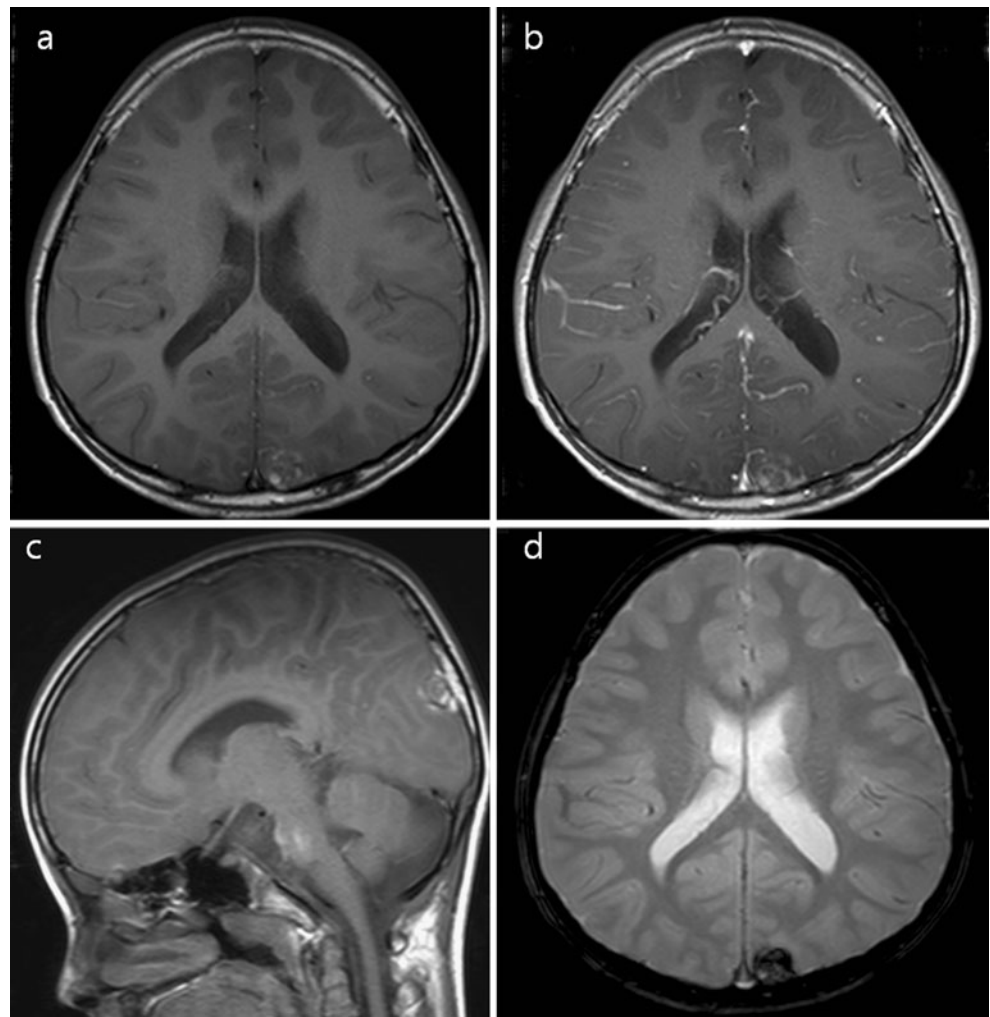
Preoperative magnetic resonance images demonstrating an occipital mass lesion. (a) T1-weighted axial image showing a mass lesion with heterogeneous signal intensity. (b) T1-weighted axial image with contrast enhancement. (c) T1-weighted sagittal image indicating a hypo-intense rim surrounding the mass lesion. (d) Dark signal in gradient-echo protocol suggesting bleeding in the mass
